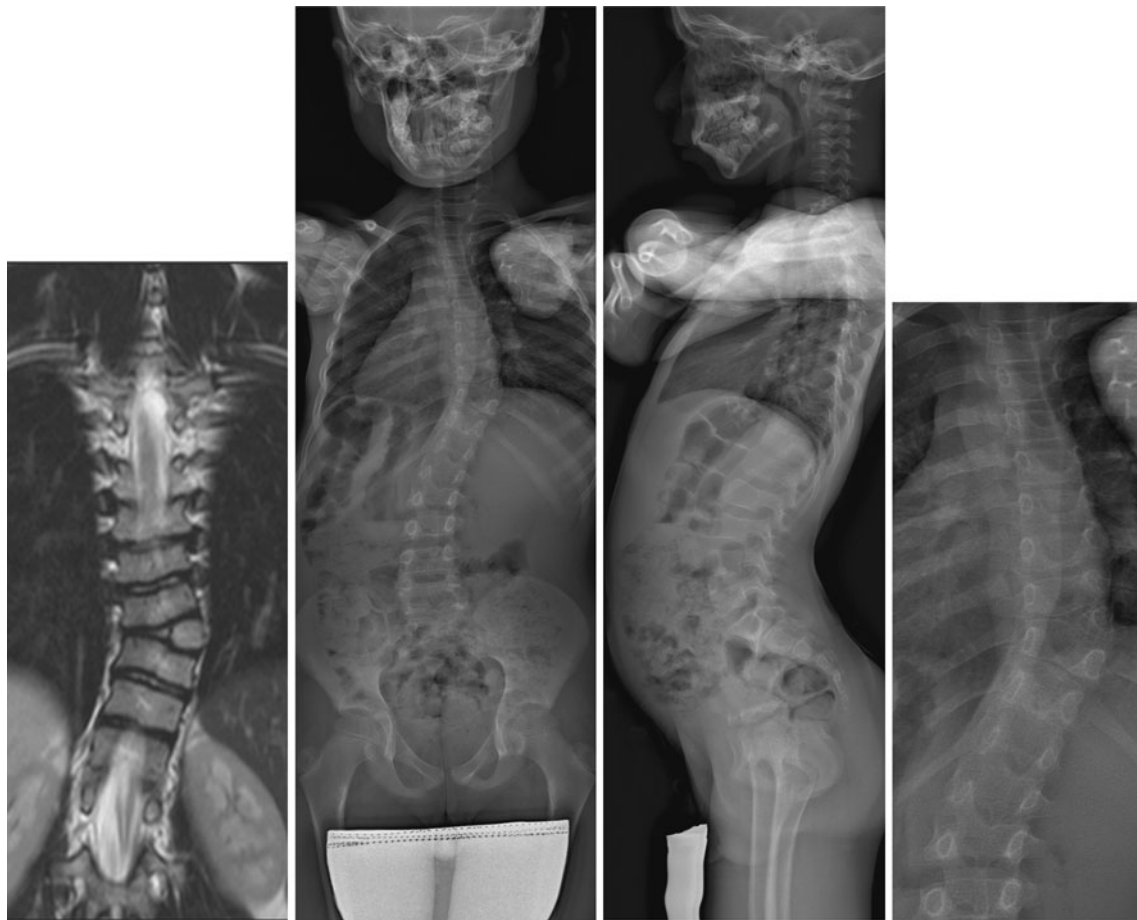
Pre-operative MRI and EOS X-rays showing T9 right hemivertebra and congenital scoliosis
